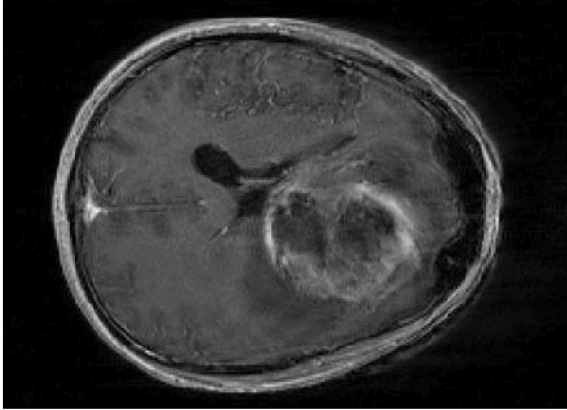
Demonstration slice  $DSlice$  that will be used to show the changes that occur when implementing each of the three steps of the proposed skull-stripping algorithm. A transversal T1-weighted MRI presenting an enhancing GMB tumor.
